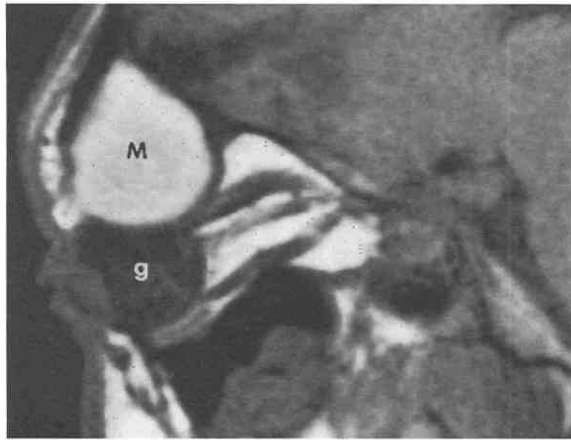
Sagittal T1-weighted MRI study shows mucocoele (M) of the frontal sinus with inferior displacement of the globe (g).
